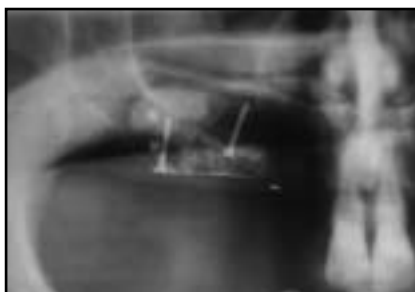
Orthopantomogram demonstrates bone graft and membrane in position.
